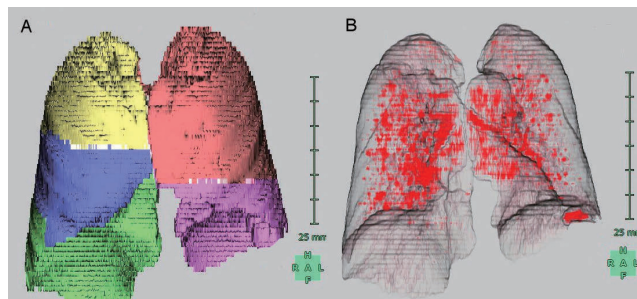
An example of lobar segmentations and LAA on 3D-CT images.
